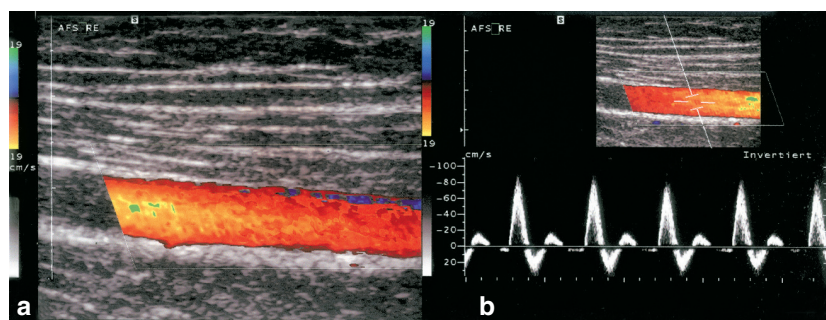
Normal superficial femoral artery. a) Color Doppler US shows a laminar flow without turbulences. b) Triplex mode reveals triphasic normal spectrum with a systolic peak velocity of 90 cm/s, a short diastolic reflux followed by an end-diastolic forward flow.
